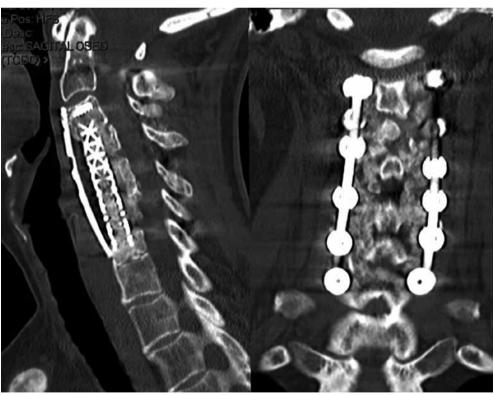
CT scan two years after the surgery.
